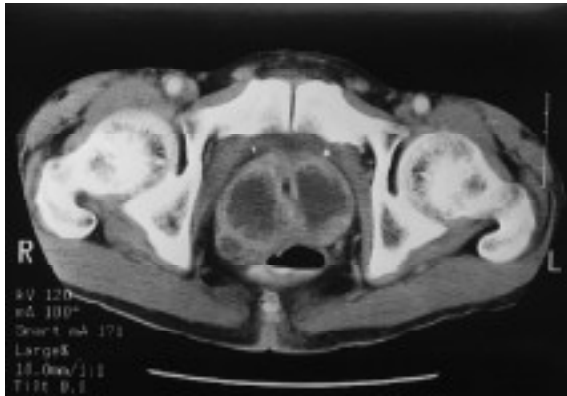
Enhanced CT scan of the pelvis taken at the mid-portion of the prostate shows extensive cystic changes involving the entire gland. There is prominent septal and rim enhancement.
